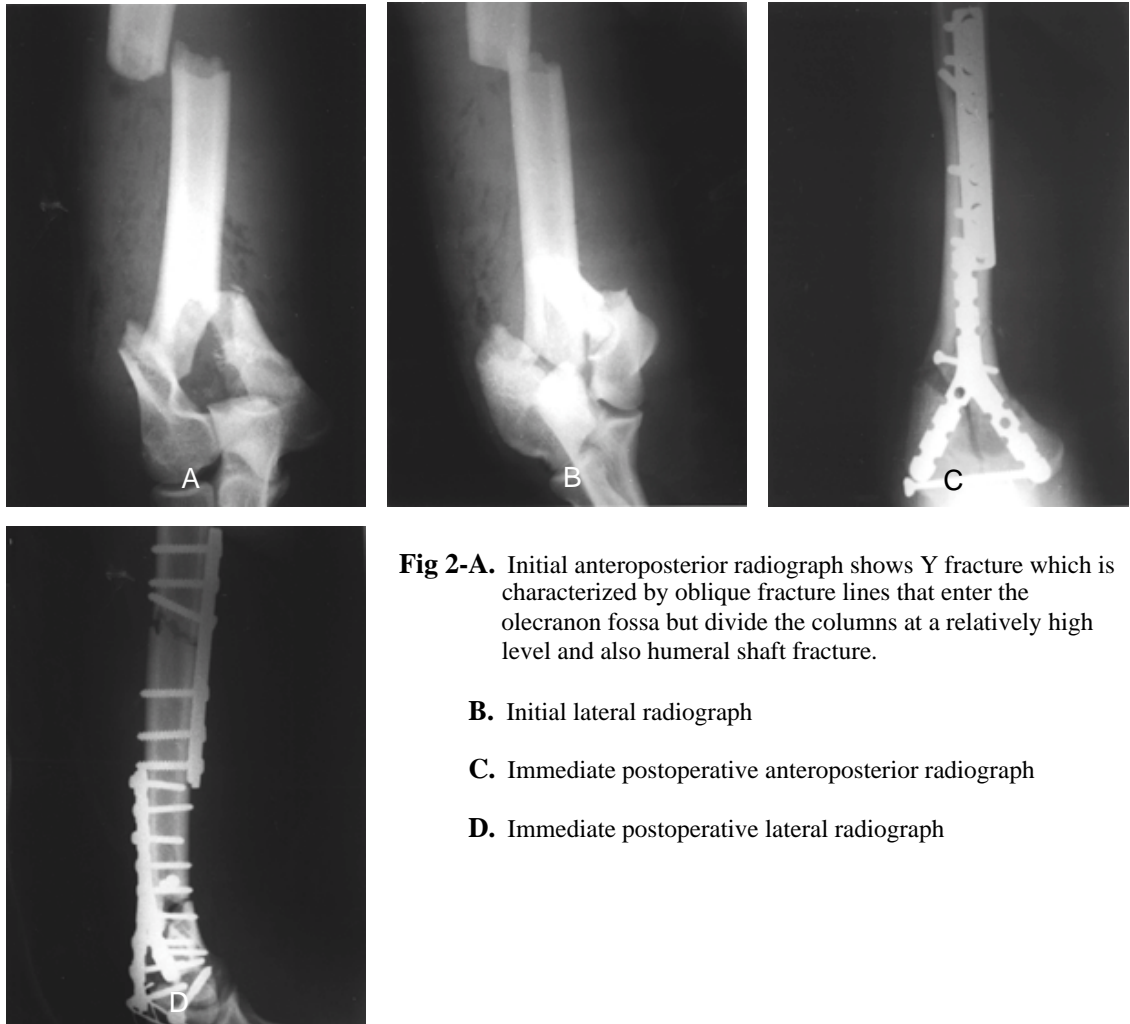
Initial anteroposterior radiograph shows Y fracture which is characterized by oblique fracture lines that enter the olecranon fossa but divide the columns at a relatively high level and also humeral shaft fracture.
